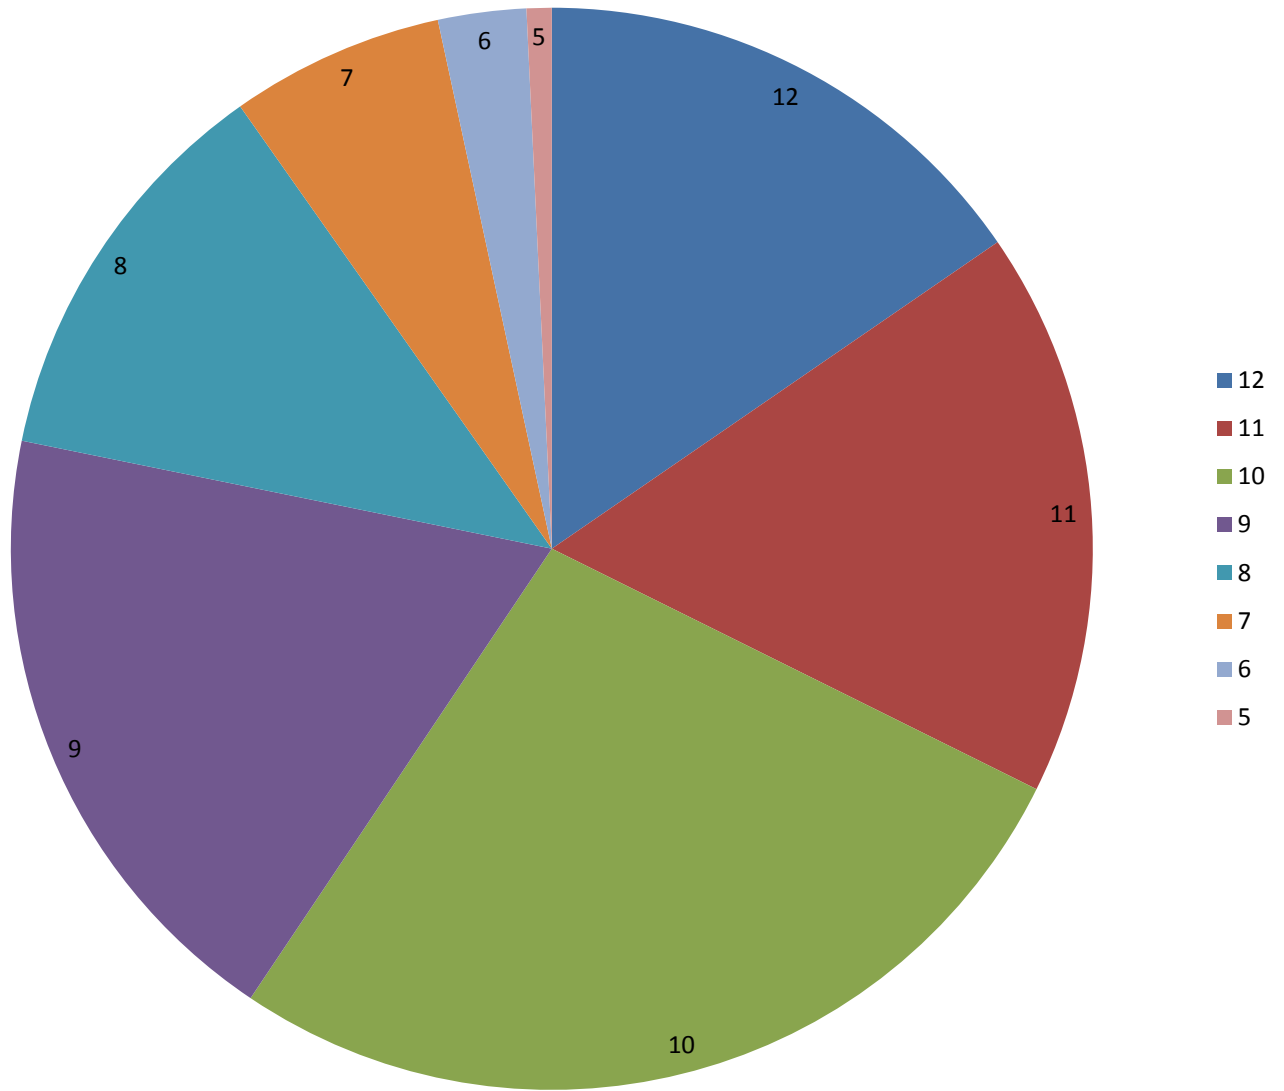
Criteria met by radiographs
